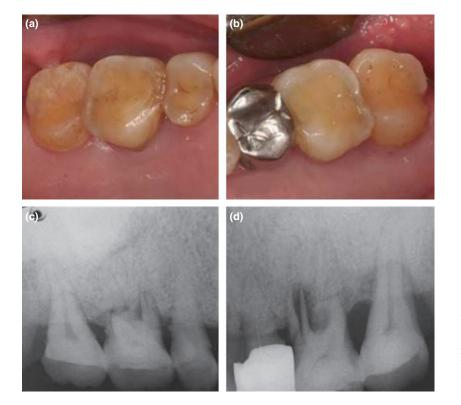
Occlusal wear on the maxillary right first molar (a) and left first molar (b). Radiographs of the maxillary right first molar (c) and left first molar (d) showing vertical fractures in the mesiobuccal root and horizontal fractures in the palatal root.
